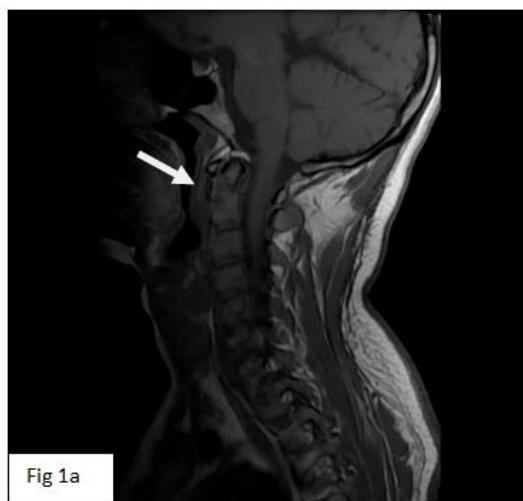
T2 SAG MRI, Figure 1b axial CT: shows type II comminuted fracture with superior displacement of fracture fragments and posterior displacement of the other adjacent fracture fragments with mild ventral thecal sac indentation
